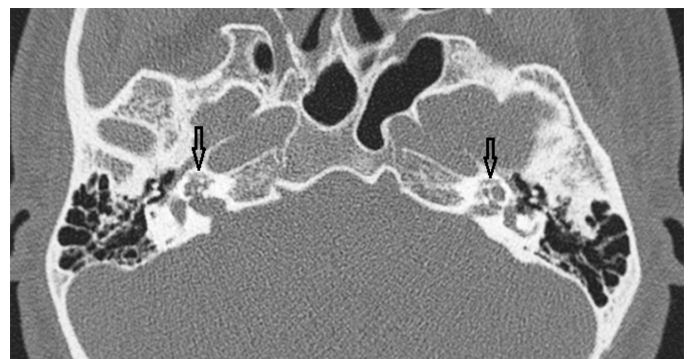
Temporal high-resolution computed tomography scan of a 27-year-old male patient presenting with tinnitus revealed bilateral retrofenestral otosclerosis, as indicated by black arrows
